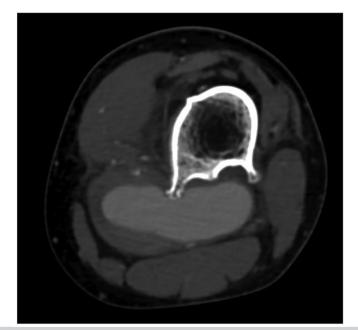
Axial computed tomography angiography revealed popliteal artery pseudoaneurysm secondary to erosion of an adjacent femoral exostosis.
